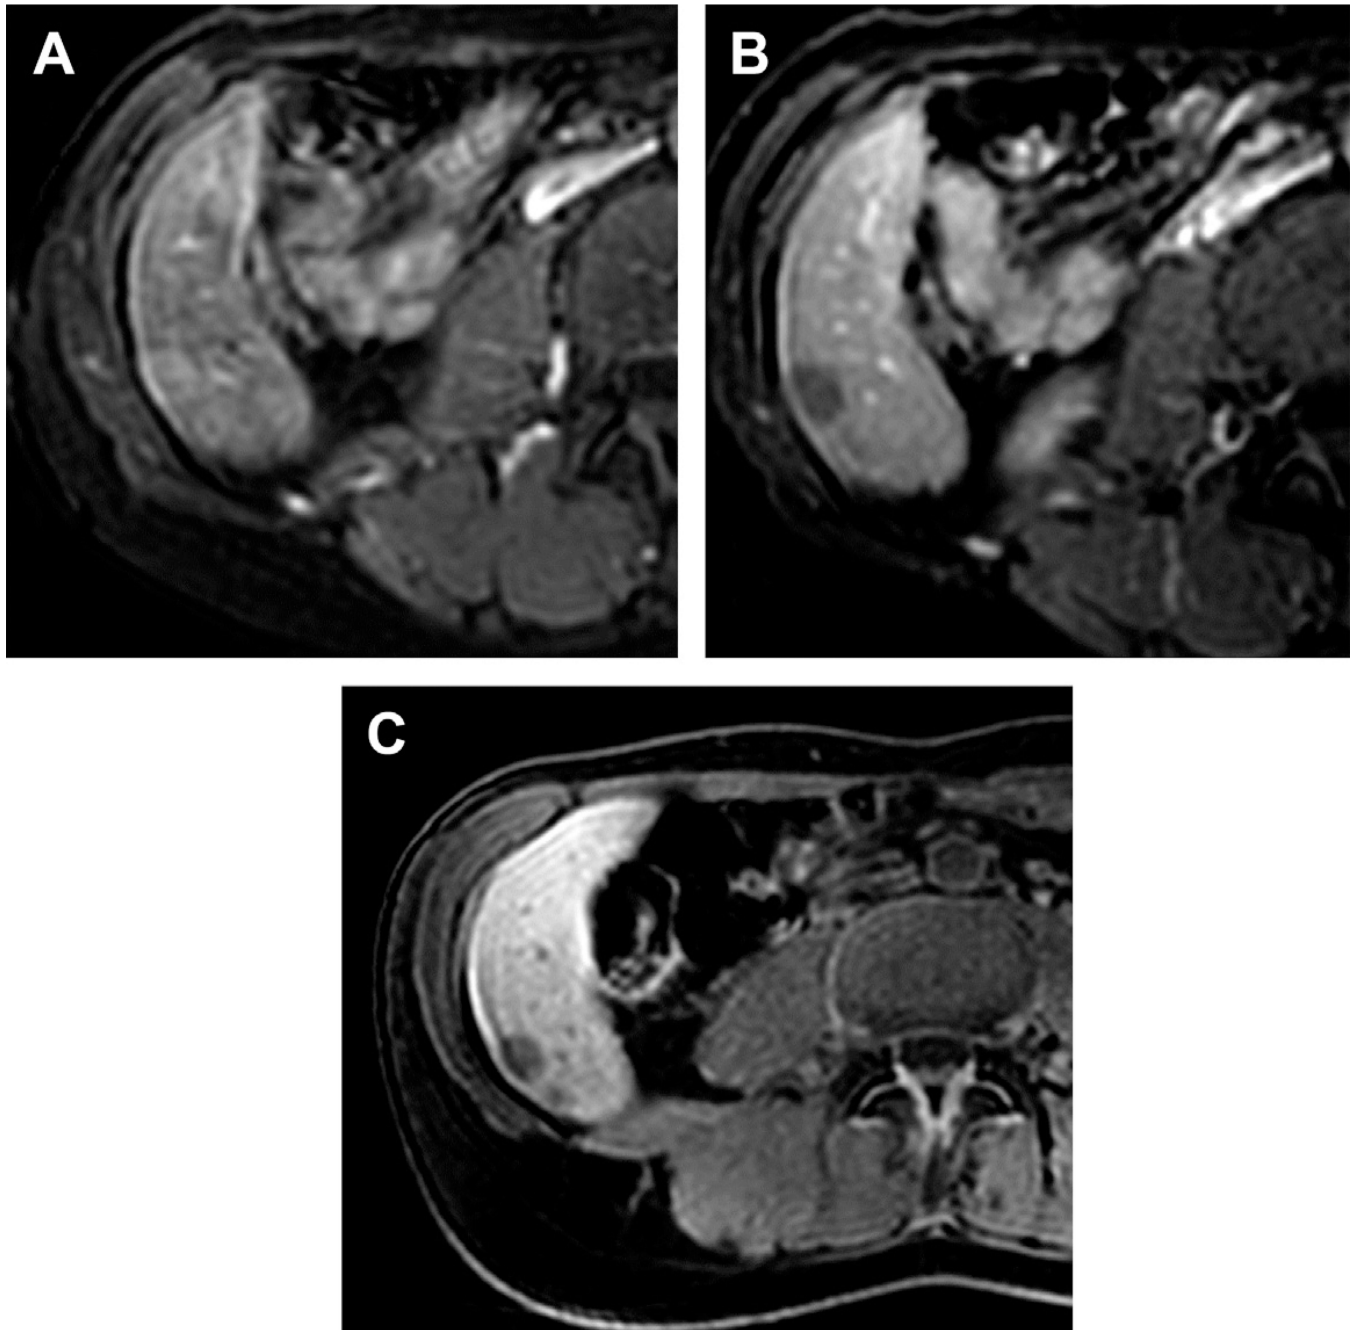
Hepatocellular adenoma with Gd-BOPTA. (A, B) DCE-MR imaging during arterial and venous phases demonstrate a nodule with enhancement on arterial phase and delayed washout. (C) Notice the absence of enhancement during the HB phase.
